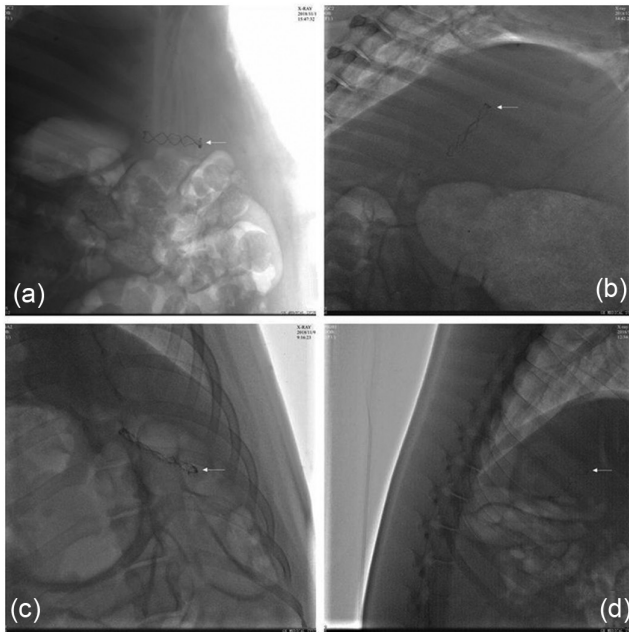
The stent degradation process under x-ray examination ((arrow shows the lead mark) (A) normal structure; (B) partial structural deformation; (C) complete structural deformation; (D) chaotic structure.
